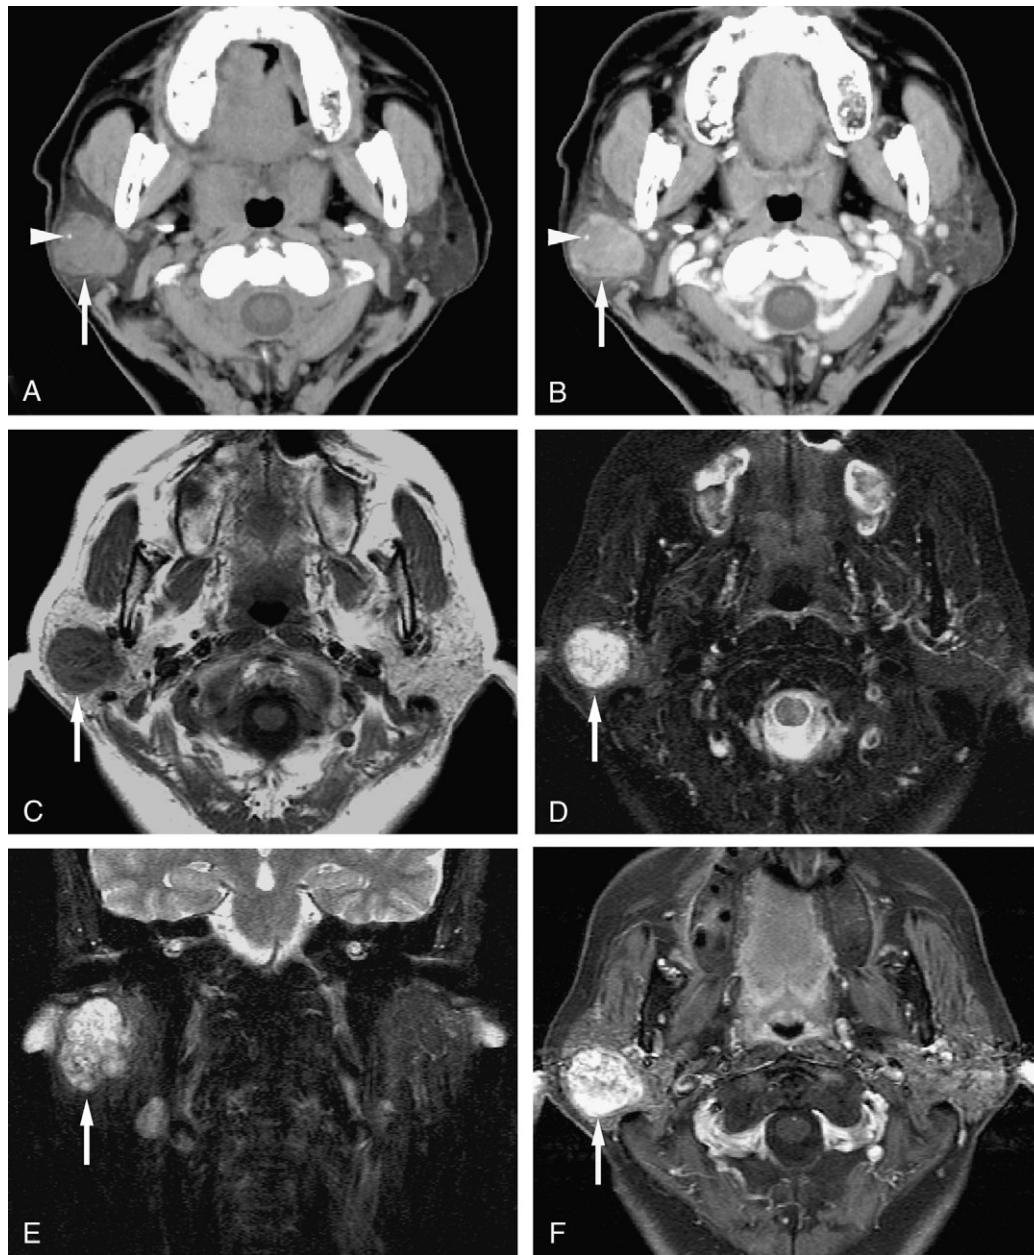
Pleomorphic adenoma of the parotid gland in a 57-year-old female. A well-defined margin tumor (arrows) can be detected on both CT and MR images. The CT image shows calcification in the tumor (arrowheads). (A) The tumor shows an inhomogeneous intermediate signal intensity on a plain CT image. (B) After contrast medium administration the tumor shows an inhomogeneous enhancement on a CE CT image. (C) The axial T1-weighted MR image shows an intermediate signal intensity mass. (D) On an axial T2-weighted MR image using the FS technique, the tumor shows an inhomogeneous high signal intensity mass and the capsule can also be detected. (E) The tumor shows a lobulated border on a coronal T2-weighted MR image using the FS technique. (F) After contrast medium administration the tumor shows an inhomogeneous enhancement on a CE T1-weighted image using the FS technique.
